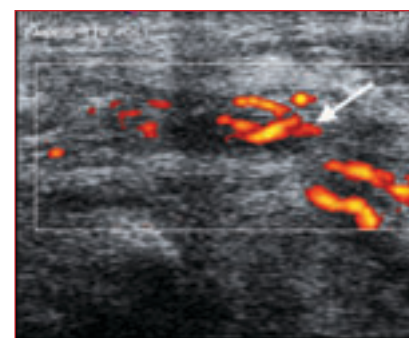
Power Doppler ultrasound showing increased vascularity of tibialis posterior tenosynovitis.
